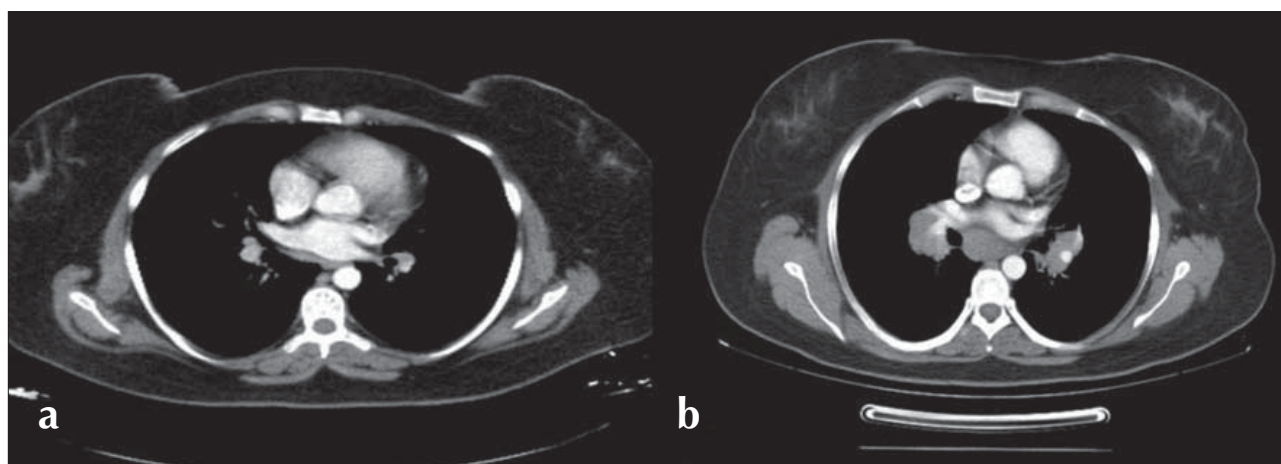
a, b. Axial view of thorax CT of the patient: (a) before treatment of CS and (b) after treatment of CS. CS: Cushing syndrome.
